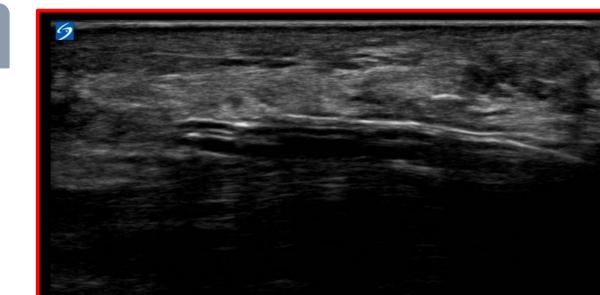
A. Picture of device with balloons expanded and hook knife deployed. B. Sonographic image of hook knife cutting TCL. Left = proximal, Top = superficial.
